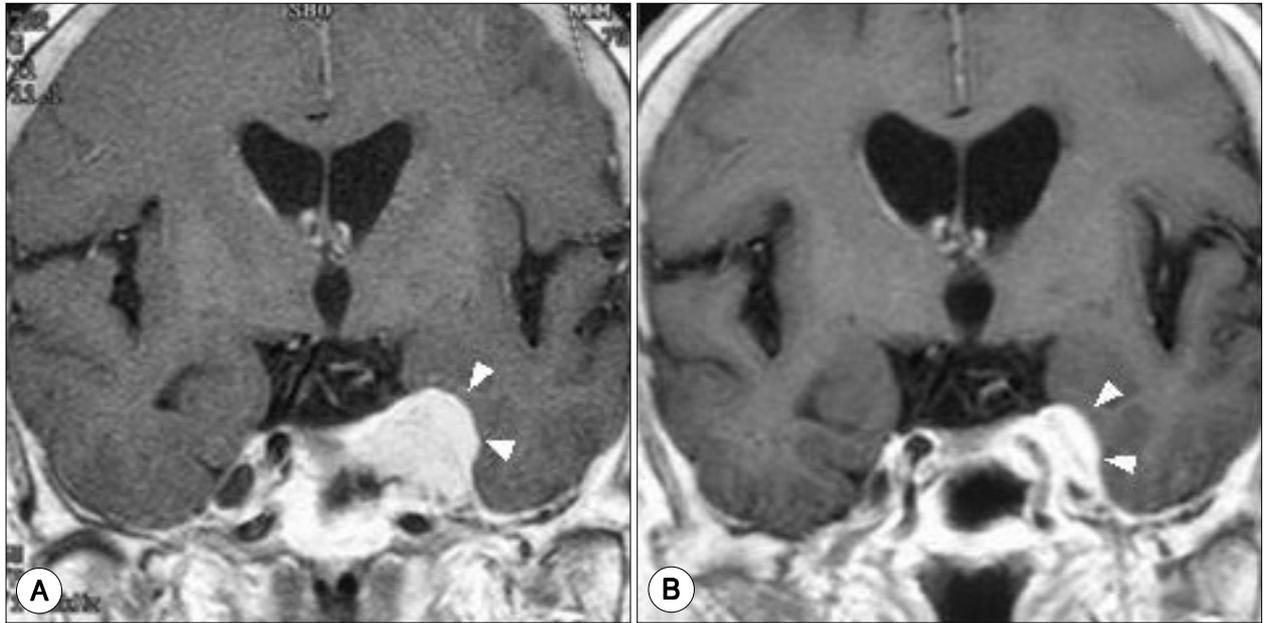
A : Pre-radiosurgical MRI showing left cavernous sinus and Meckel's cave meningioma. B : Follow-up MRI(14 months after Gamma Knife radiosurgery) showing sh-rinked tumor.
